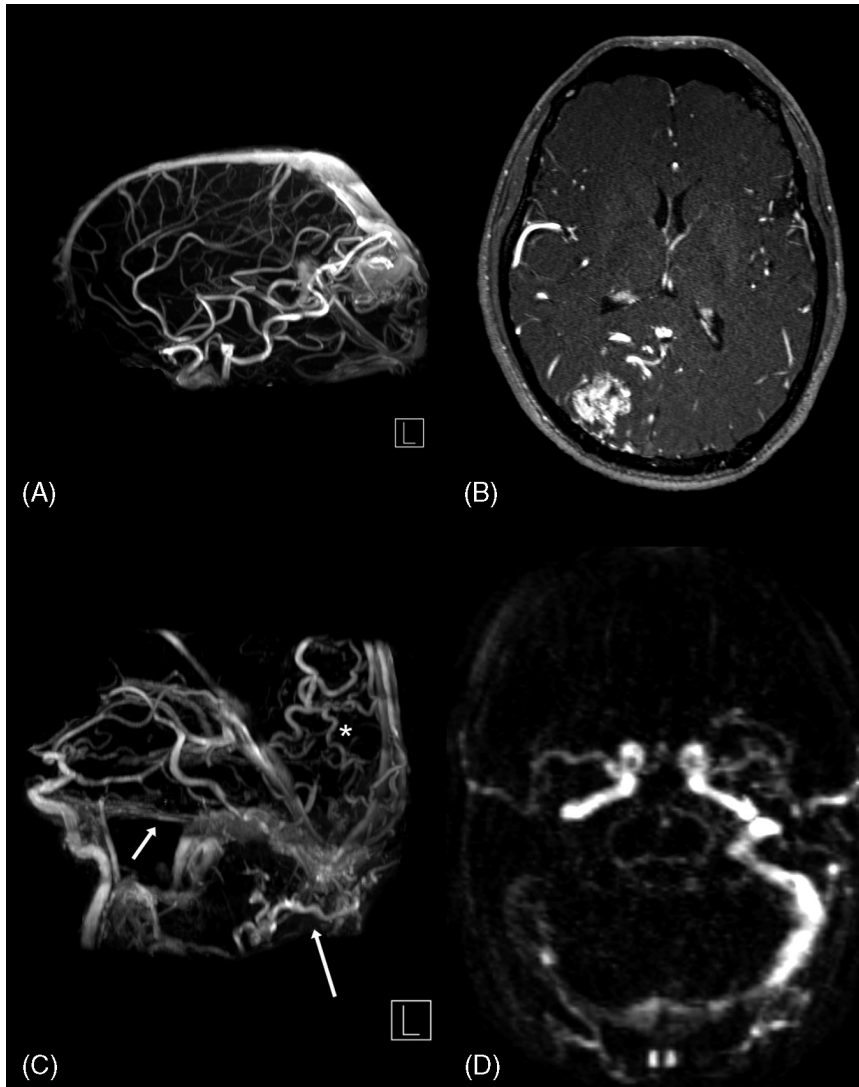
An occipital arteriovenous malformation imaged by contrast enhanced TOF-MRA and selective maximum-intensity projection for an improved visualization of high flow vessels and venous structures (A). Intra-arterial angiography is always necessary for treatment planning, but source images of MRA are useful to locate the arteriovenous malformation in relation to eloquent brain regions (B). Dural AV fistula (C) by the same technique: Feeding arteries (the external occipital artery and the meningohypophyseal trunk) may be identified as well as the draining sinus and dilated cortical veins (*). Time-resolved MRA (D) reveals rapid shunting into the transverse and sigmoid sinus—otherwise a fistula may be missed on conventional MRI or even MRA.
